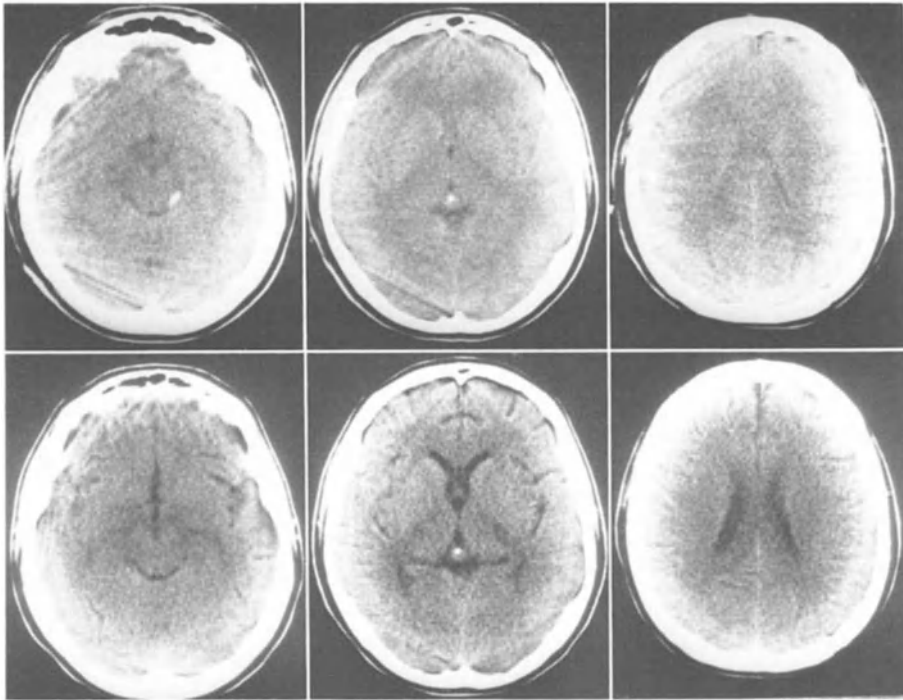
This adolescent injured in a traffic accident scored 5 points when admitted to our unit. He showed alternating pupillary changes during the first three days after injury. The admission CT scan showed discrete generalized brain swelling with small intraparenchymal haemorrhages in the corpus callosum and the dorsolateral mesencephalon. ICP ranged between 20–30 mmHg and was easily controlled. Coma lasted for three weeks and the final outcome was moderate disability
